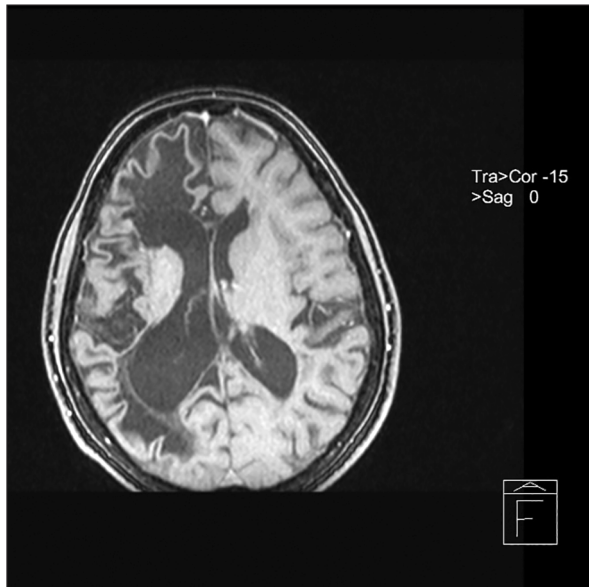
Cerebral MRI – large left lateral ventricle
